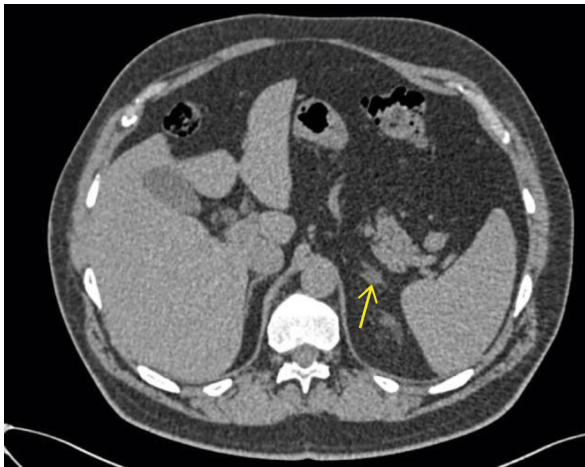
Original adrenal computed tomography image revealing a 9-mm adrenal adenoma measuring 2 Hounsfield units (arrow). As the bladder was not visualized on this scan, this was initially thought to be a pheochromocytoma.
